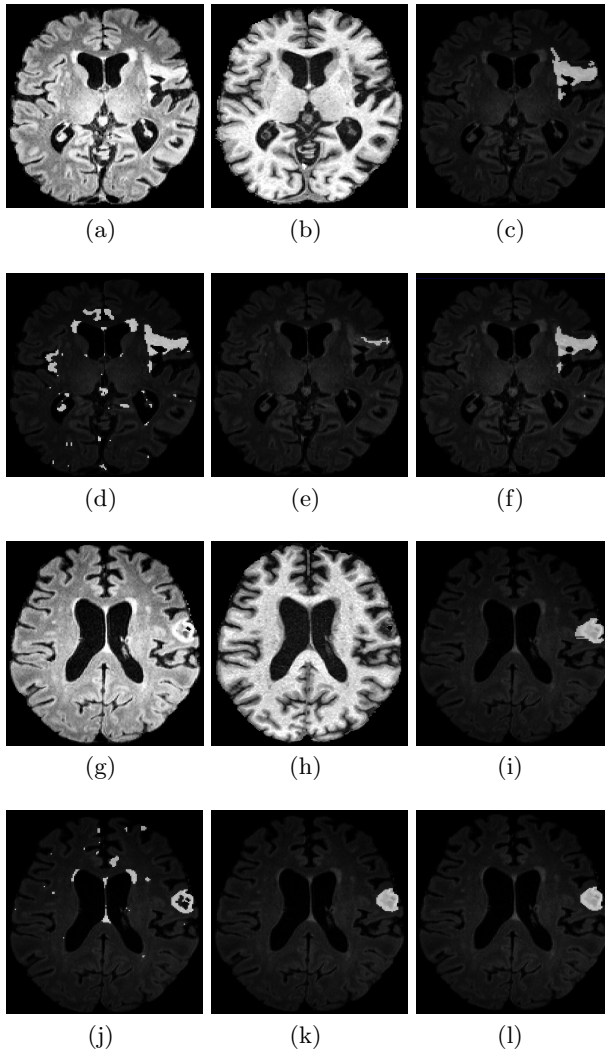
Classification results from MRF, RF and connected component analysis. (a) to (f) are the results corresponding to patient 1 and (g) to (l) are the results corresponding to patient 2. (a) & (g) are the FLAIR images that show hyperintensities for stroke lesions and (b) & (h) are the T1W images showing hypointense regions of stroke. The manual segmentations by the expert radiologist are shown in (c) & (i); segmentations from MRF (merged 3-classes) are shown in (d) & (j); segmentations from RF classifications are shown in (e) & (k) and the final lesions after ad-hoc connected component analysis are shown in (f) & (l) for patients 1 and 2 respectively.
